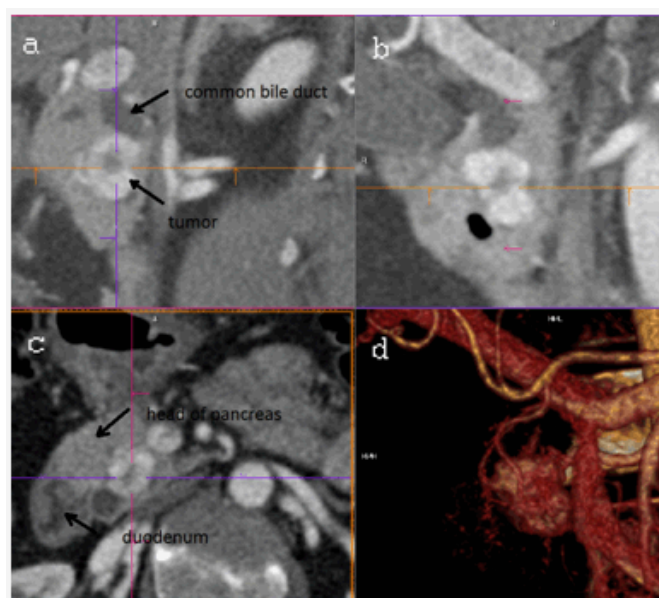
The initial computed tomography scan with cross sections in three basic dimensions and a volume rendering (bottom left corner) revealed a tumor within the head of the pancreas, which was adjacent to the common bile duct and showing intensive contrast enhancement.
